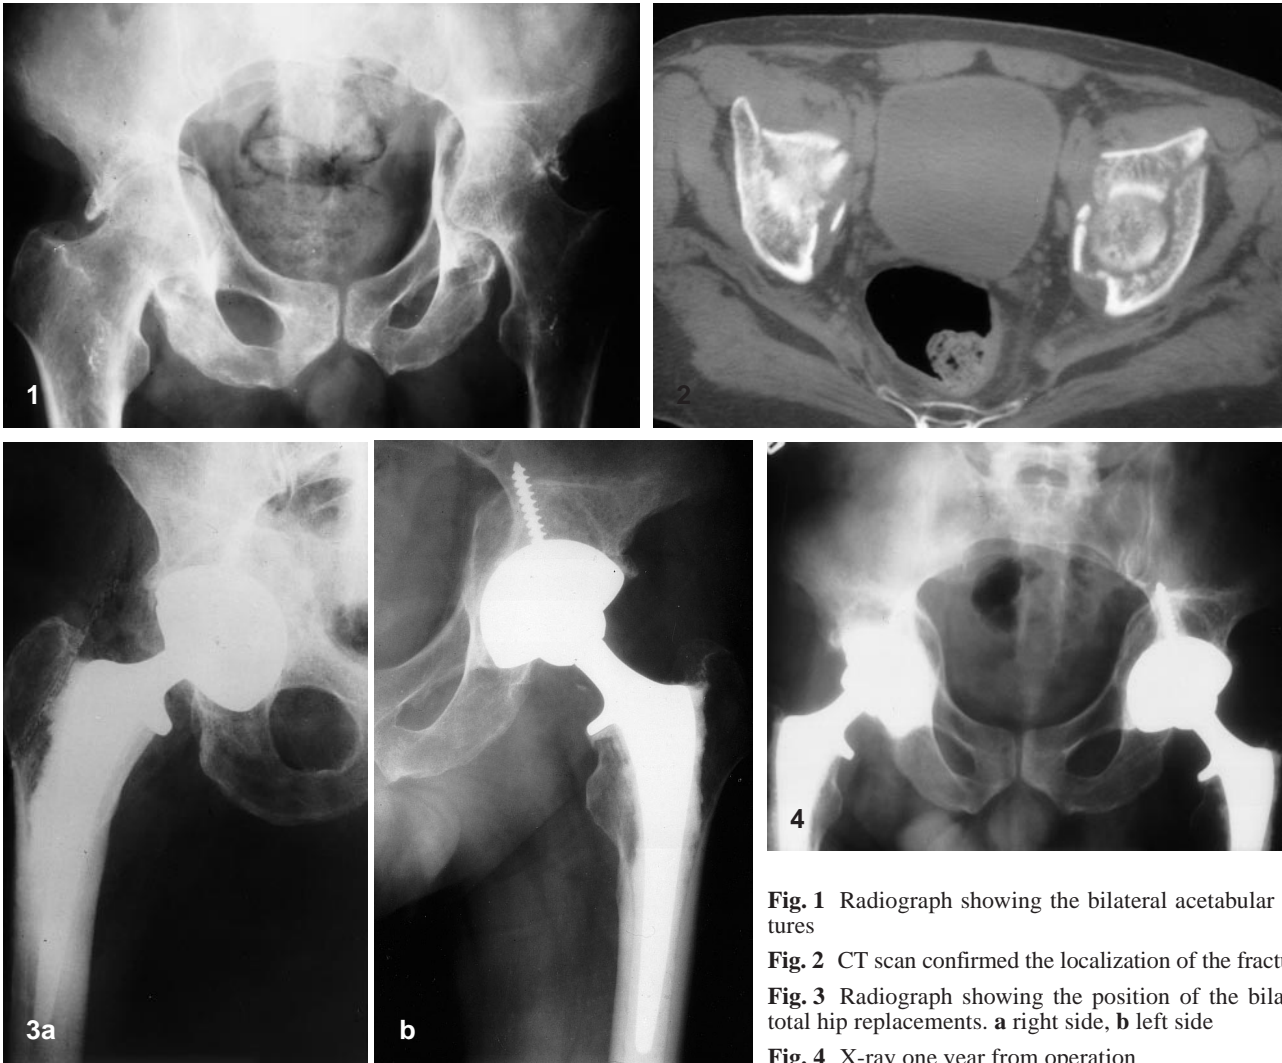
Radiograph showing the bilateral acetabular fractures
